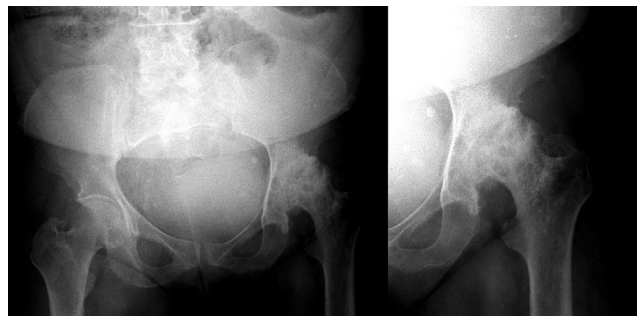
Anteroposterior (AP) pelvic x-ray (left) and AP left hip x-ray (right) of a 67-year-old female with left sided hip osteoarthritis.
